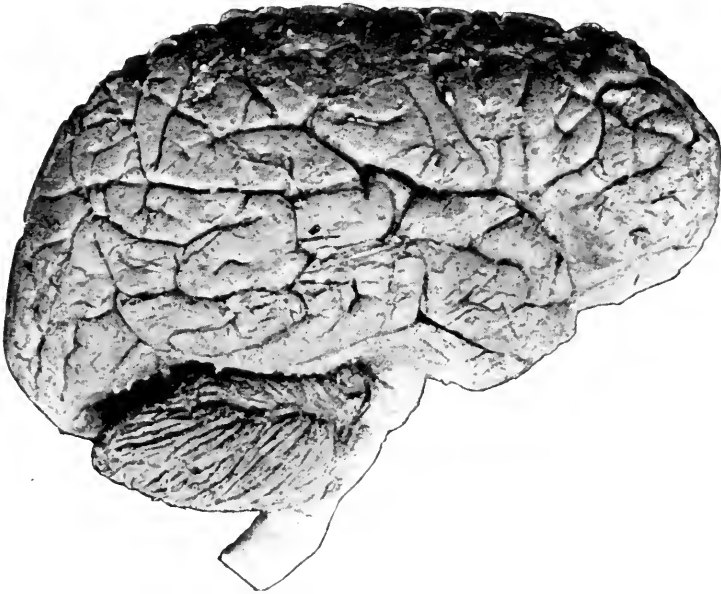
PHOTOGRAPH OF THE HUMAN BRAIN FROM THE LATERAL ASPECT.
